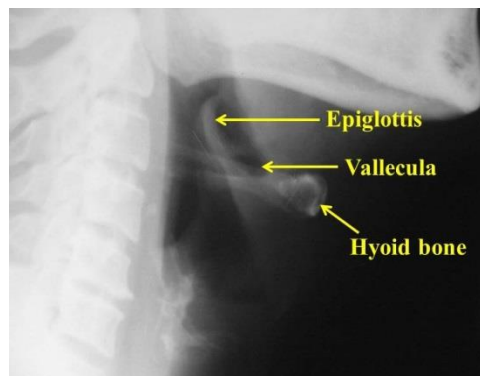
Plain X-ray, lateral view of the neck
